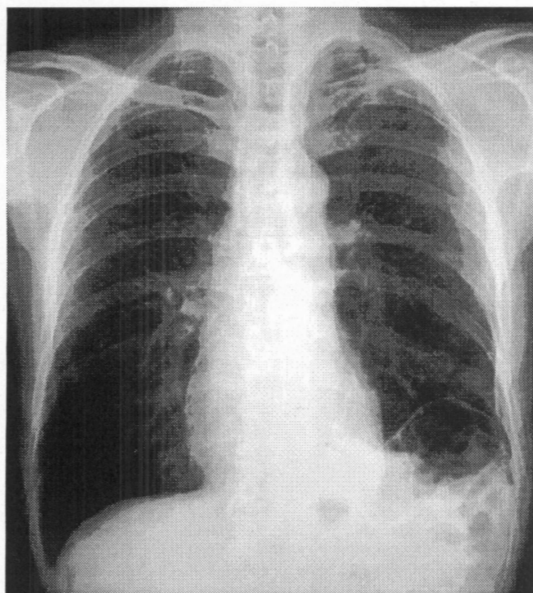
Chest radiograph showed the gas image that allows suspicion of an existing bowel on the left diaphragm.
